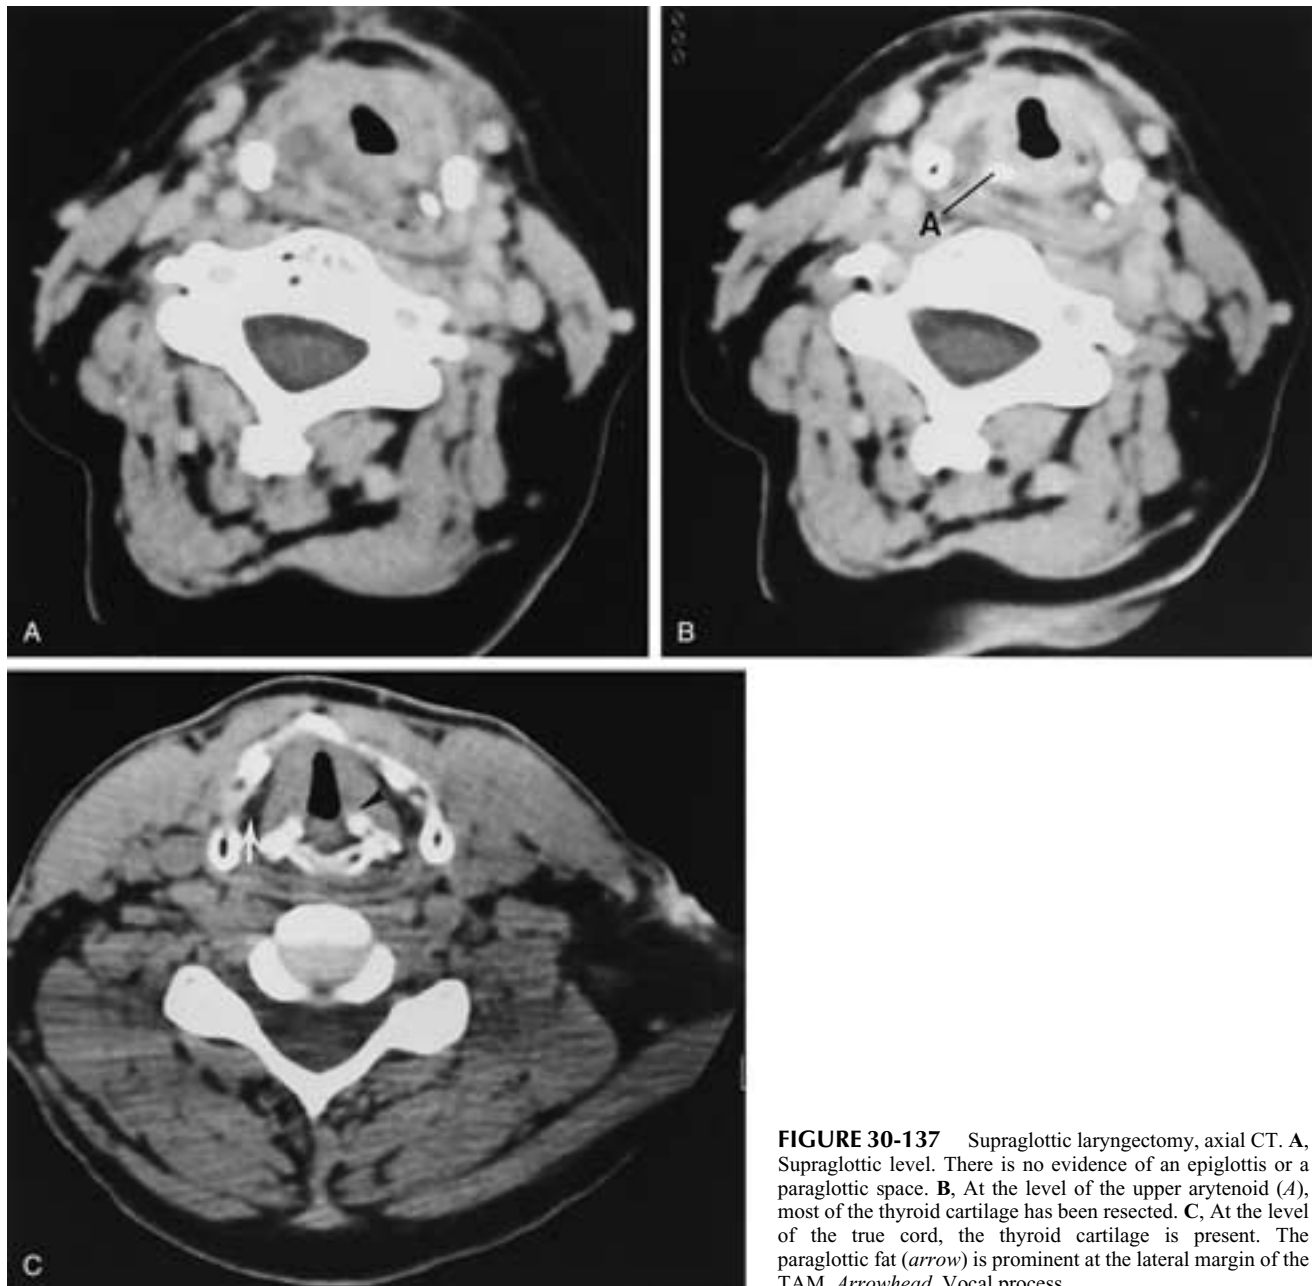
Supraglottic laryngectomy, axial CT. A, Supraglottic level. There is no evidence of an epiglottis or a paraglottic space. B, At the level of the upper arytenoid (*A*), most of the thyroid cartilage has been resected. C, At the level of the true cord, the thyroid cartilage is present. The paraglottic fat (*arrow*) is prominent at the lateral margin of the TAM. *Arrowhead*, Vocal process.
